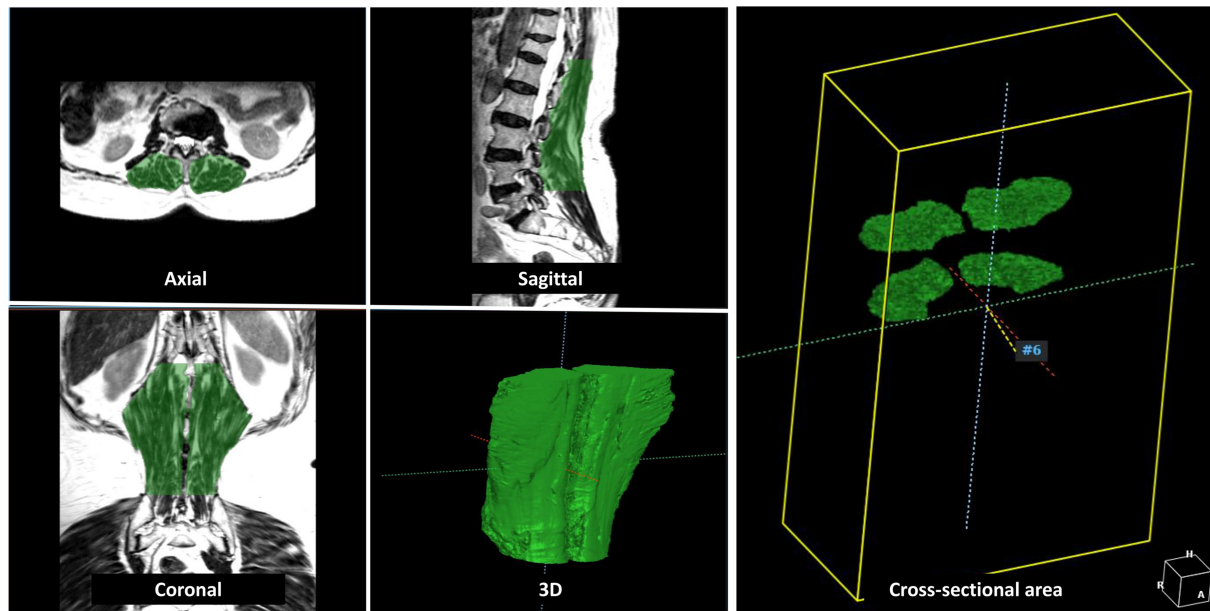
Three-dimensional segmentation of lumbar paraspinal muscles in L-S spine magnetic resonance imaging.
